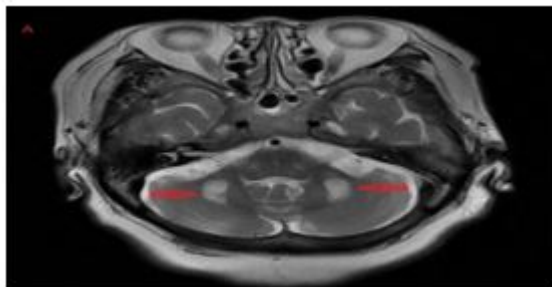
T2-weighted MRI findings of the cerebellar peduncle. T2-weighted MRI showed the lesion of the cerebellar peduncle presented as “mushroom cloud” changes.
